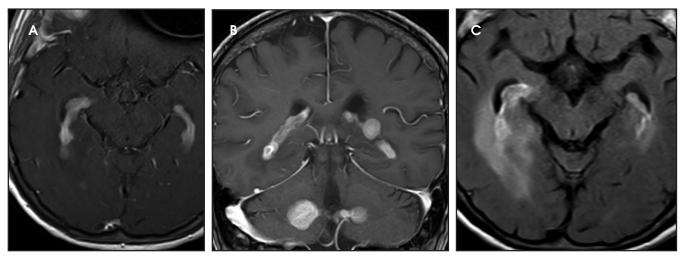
Axial (A) and coronal (B) T1 MRI images with contrast demonstrate enhancing choroid plexus lesions from lateral ventricles to temporal horns. Nodular enhancing lesions in the third ventricle, foramen of Monro, and in the fourth ventricle extending to the foramen of Luschka are also present. (C) T2 FLAIR sequence demonstrates significant vasogenic edema surrounding the lesion.
